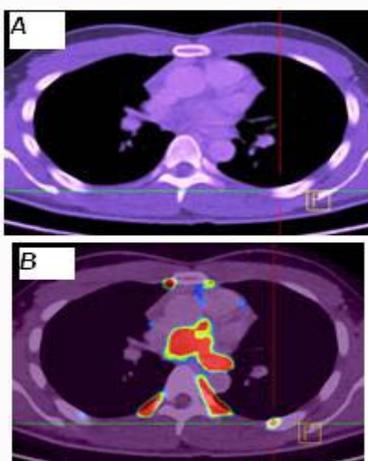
Axial CT (Figure 1a) and fused FDG PET-CT in the left (Figure 1b) images of the case described. Hairline markers demonstrate another focal FDG-avid configuration along the parietal pleura of the left lower hemithorax without discernible abnormality on CT favouring a brown fat signal.
